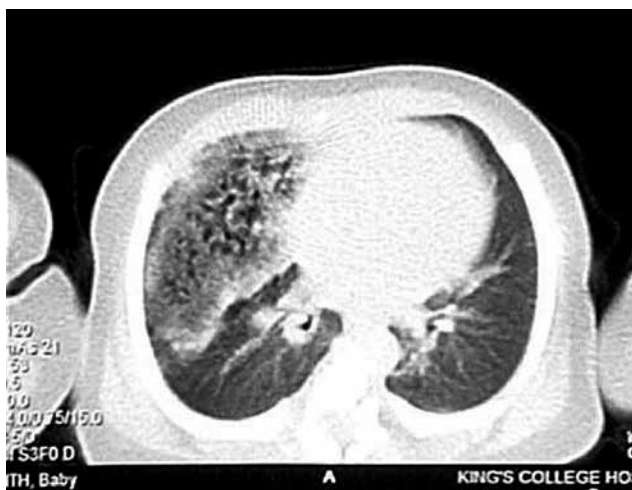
Microcystic CCAM (CT scan and intraoperative imaging)
